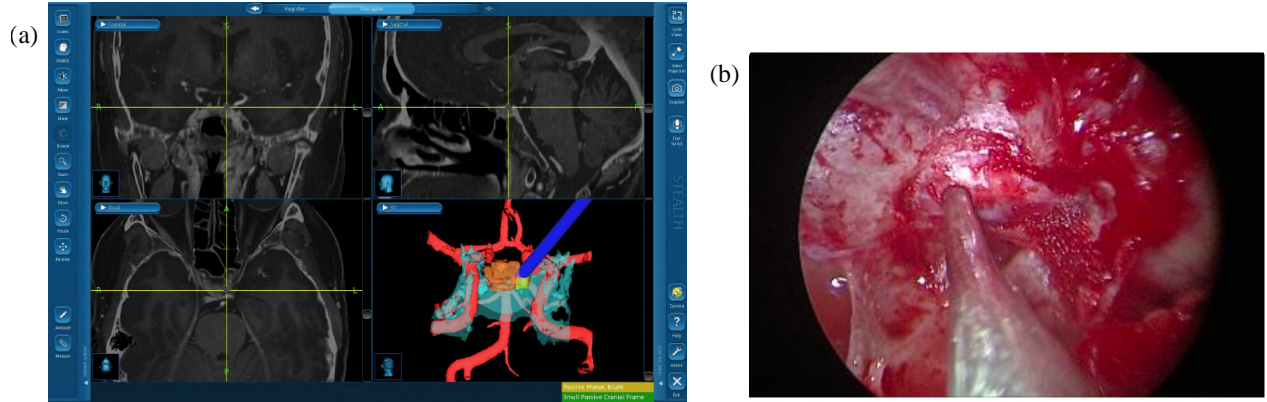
Screen captures of the live displays used to guide transsphenoidal surgery. a) Preoperative MRI: 2D views of the 3D scan and neuronavigation representation of an instrument in dark blue on the preoperative reconstruction. The normal gland is shown in orange, the adenoma in lime green, the cavernous sinus in light blue, and the arteries in red. b) Endoscopic image showing the instrument with its tip on the pituitary gland.
